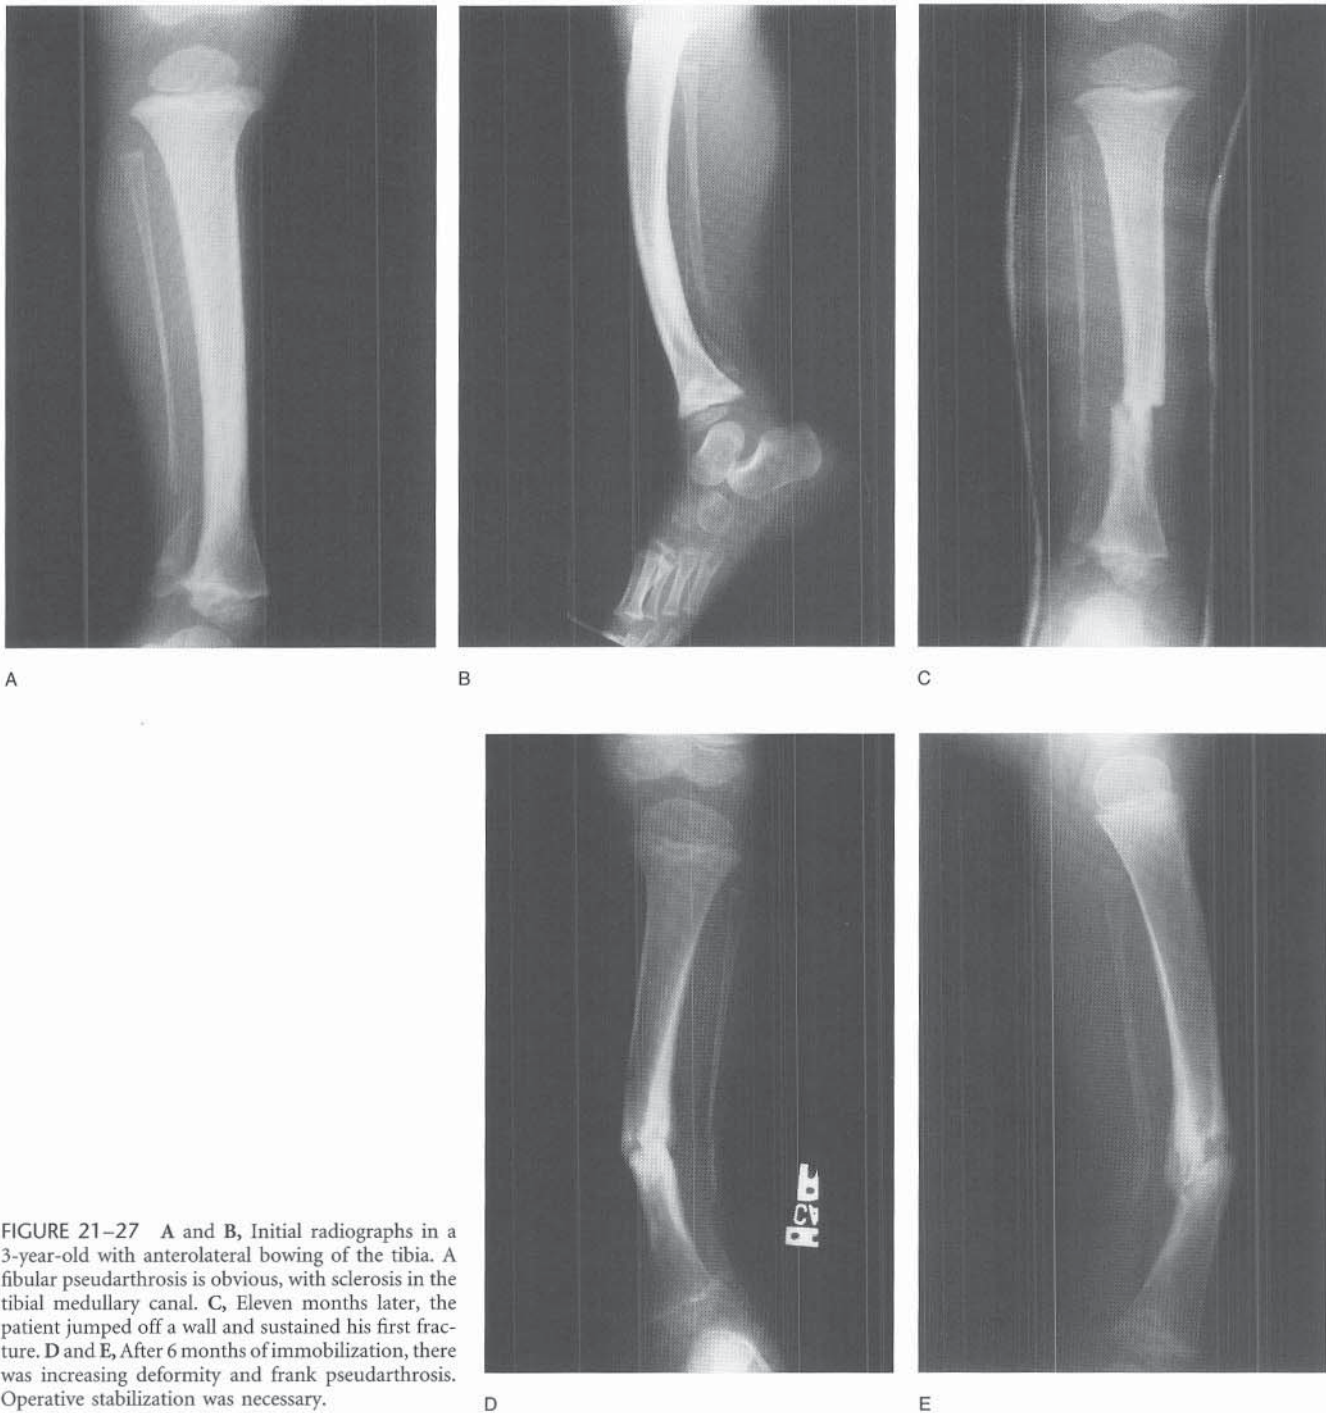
A and B, Initial radiographs in a 3-year-old with anterolateral bowing of the tibia. A fibular pseudarthrosis is obvious, with sclerosis in the tibial medullary canal. C, Eleven months later, the patient jumped off a wall and sustained his first fracture. D and E, After 6 months of immobilization, there was increasing deformity and frank pseudarthrosis. Operative stabilization was necessary.
